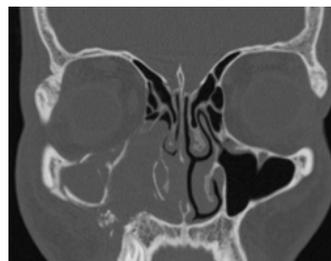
Preoperative coronal view of CT scan shows blowout fracture.
